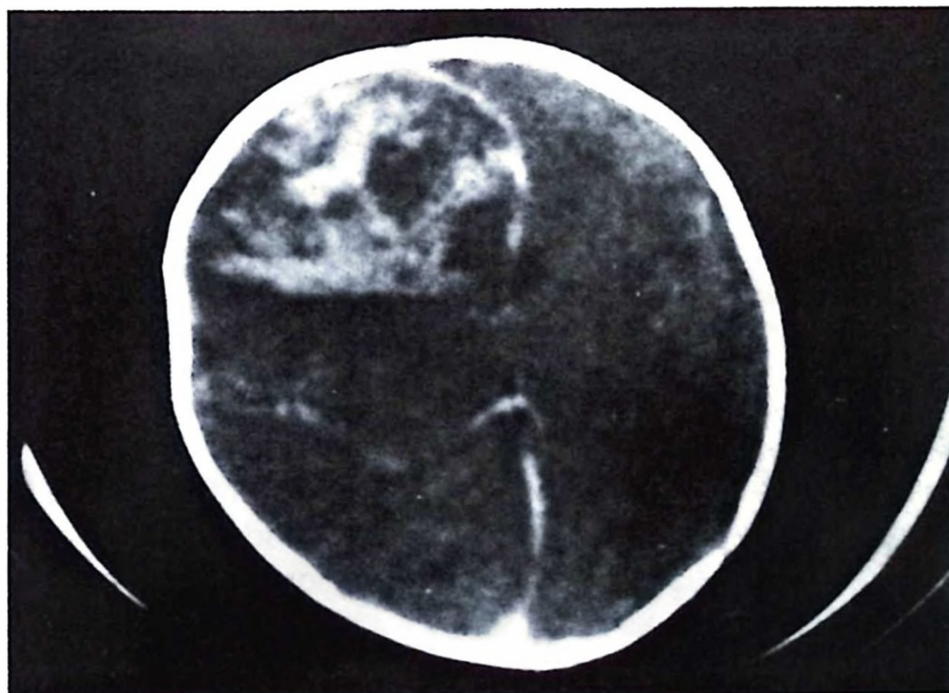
CT showed a large heterogeneous hyperdensity in the right frontal lobe, indicating intracerebral hemorrhage in the acute-subacute period and shift of interhemispheric fissure to the left side.
